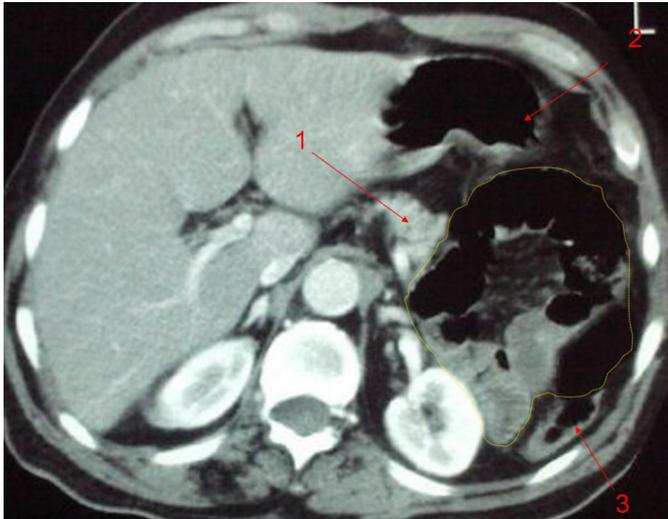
Abdominal CT showing the presence of dilated loops in the back cavity of the omentum interspersed between the pancreas (1), stomach (2) and the descending colon (3).
